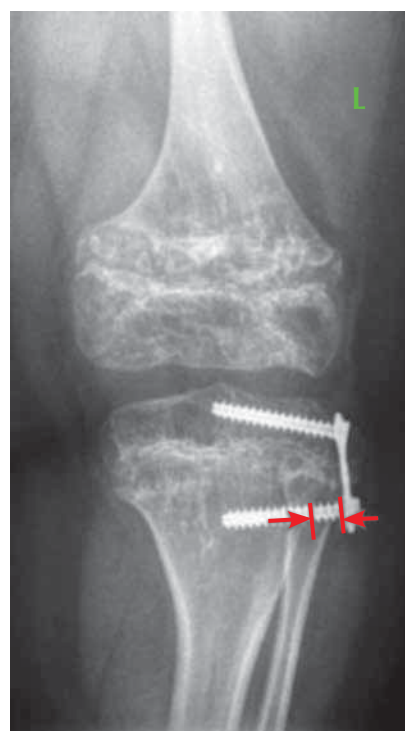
Radiograph of the left knee joint in a frontal projection of patient T., aged 10 years. The diagnosis was spondyloepiphyseal dysplasia with varus deformity of the lower limbs (arrows indicate the zone of incomplete adjoining of the plate)
